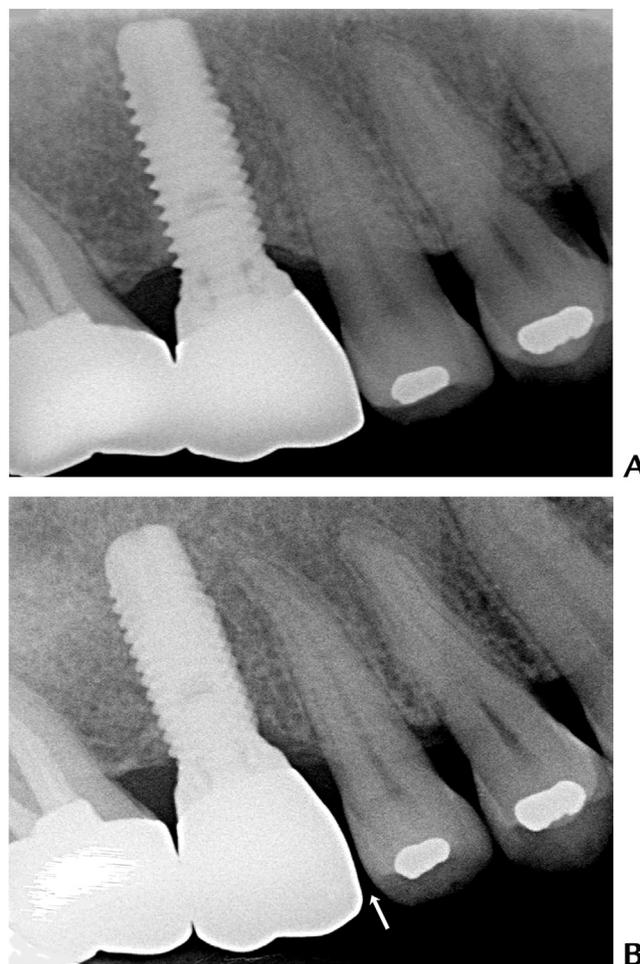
Radiographs showed proximal contacts between implant-supported fixed prosthesis (maxillary right first molar) and adjacent tooth. A, At time of delivery. B, Loss of mesial contact (white arrow) at 7.5 years follow-up.
